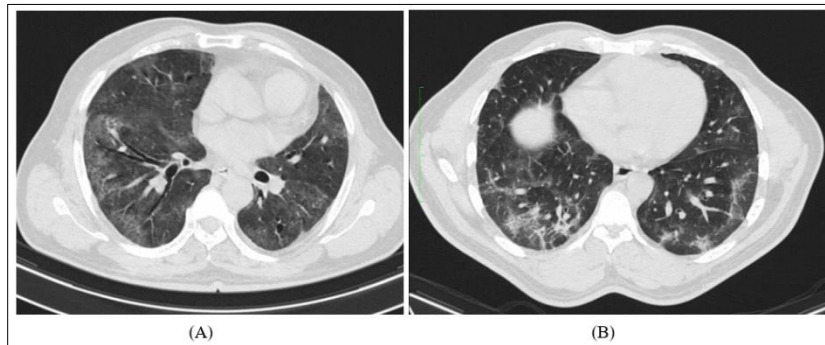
Image (A) Non contrast chest CT of 67-year-old RT-PCR positive male patient. Axial section shows characteristic ground glass opacities distributed peripherally in lower lobes along with bronchiectasis. Image (B) Non contrast chest CT of 47-year-old RT-PCR positive male patient. Axial section shows Sub-pleural fibrotic strands and areas of GGOs in posterior segments of bilateral lower lobes.
